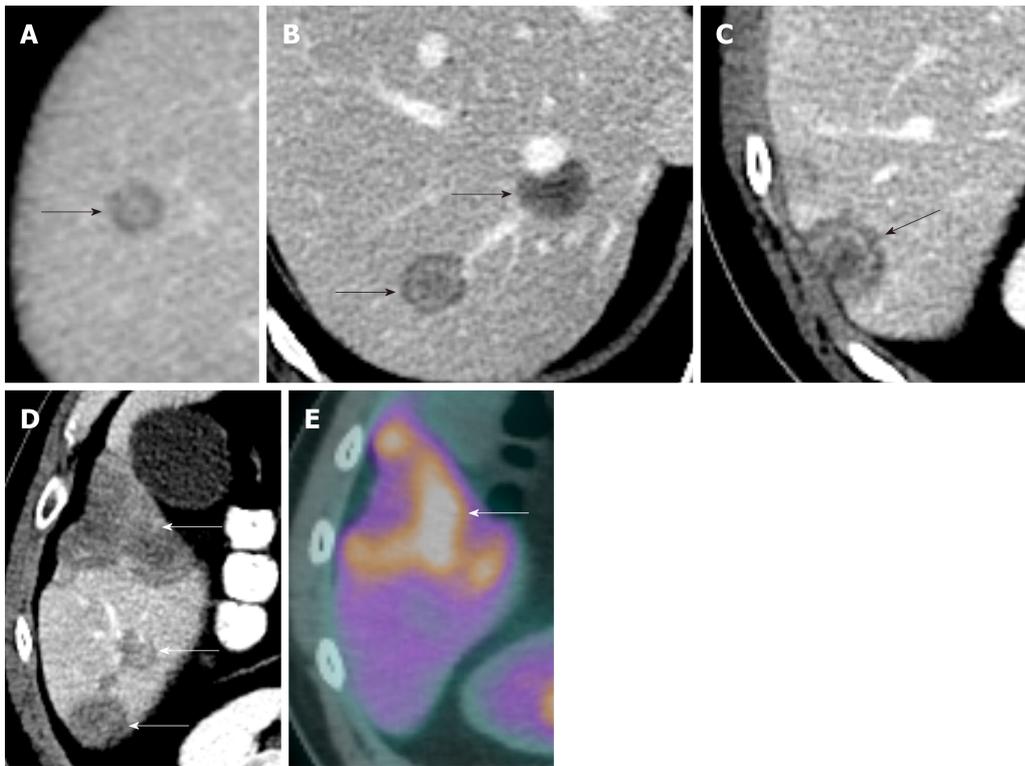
Imaging of hepatic hemangioepithelioma. A, B, C and D: Axial contrast enhanced CT images show hepatic hemangioepithelioma nodules (arrows); E: Axial ^{18}F -labeled fluoro-2-deoxyglucose positron emission tomography/computed tomography image shows a heterogeneous uptake by hepatic hemangioepithelioma nodule (arrow), while rest of the nodules showed no fluoro-2-deoxyglucose uptake.
